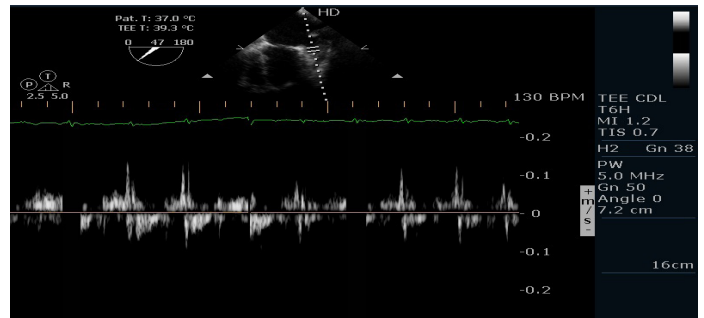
TEE with pulse wave Doppler at LAA showing reduced LAA velocities.
